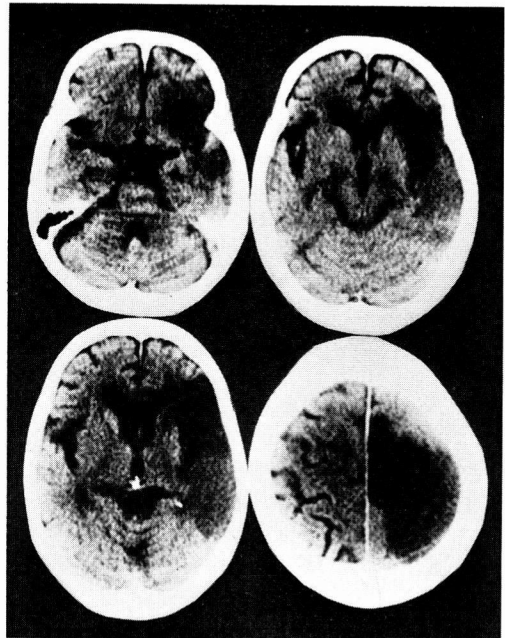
A CT scan of Case 2, demonstrating infarction in the distribution of the right anterior and middle cerebral arteries.
